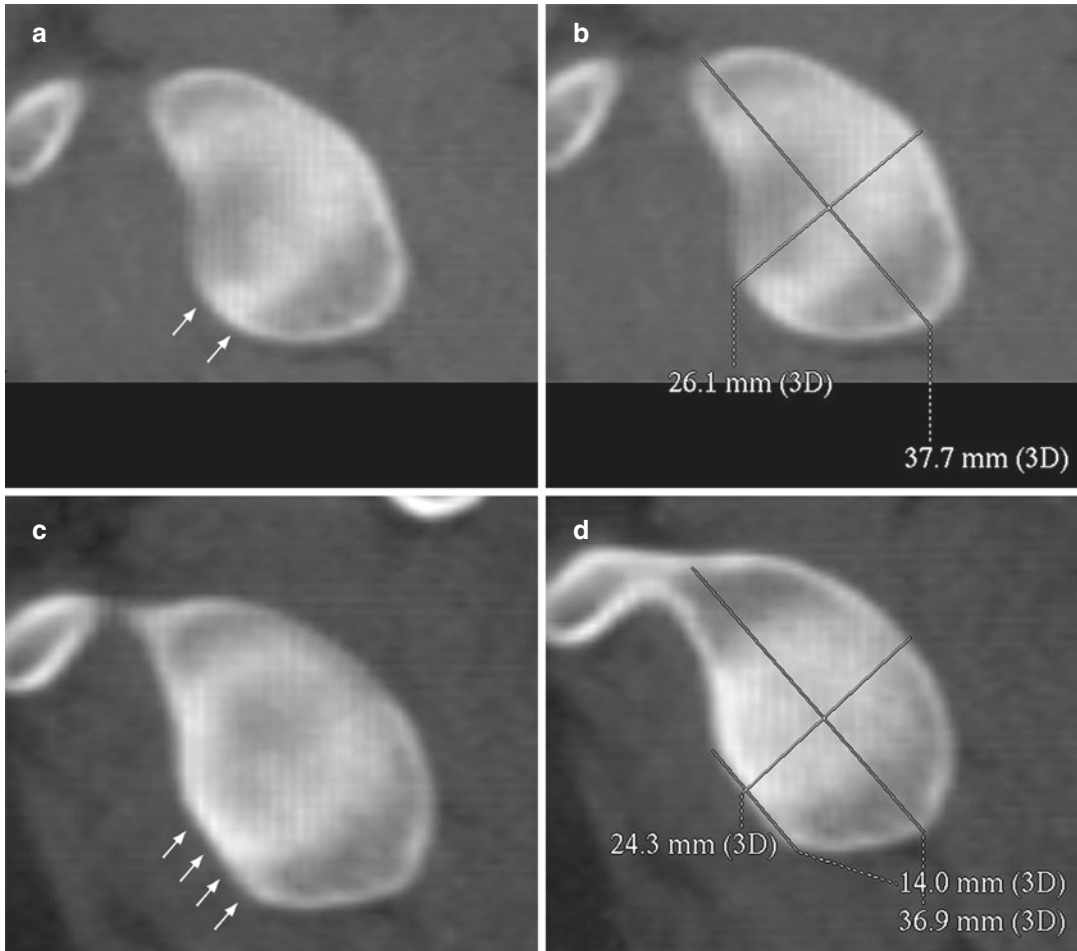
CT of the normal (a, b) shoulder showing a normal curved anterior glenoid rim (arrows) with a glenoid width of 26.1 mm. On the contralateral shoulder (c, d) with recurrent dislocation, there is loss of the normal curvature with an anterior straight line (14 mm long) to
